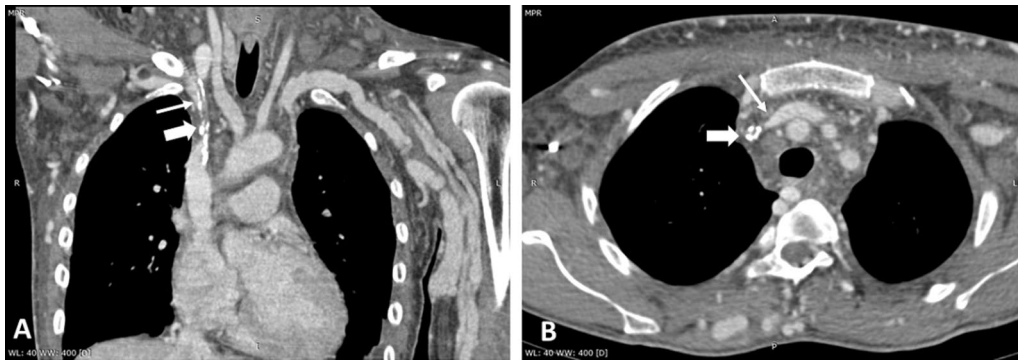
Contrasted delayed-phase CT venogram in coronal and axial view showing stenosis and non-opacification of bilateral brachiocephalic veins (thin white arrows) near the confluence extending to the upper SVC. The retained calcified sheath (thick white arrows) showed no contrast opacification within
